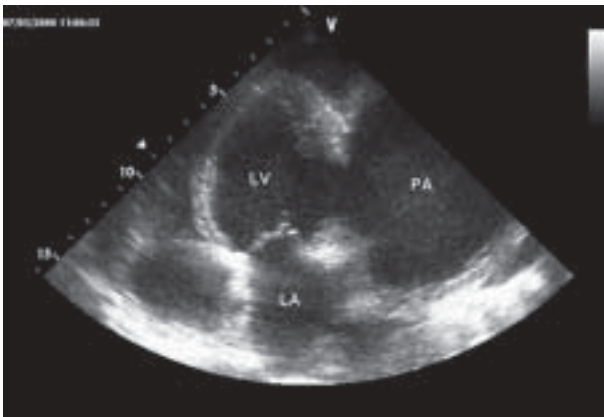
Transthoracic echocardiogram (apical four-chamber view) — giant pseudoaneurysm (PA); LV — left ventricle; LA — left atrium
